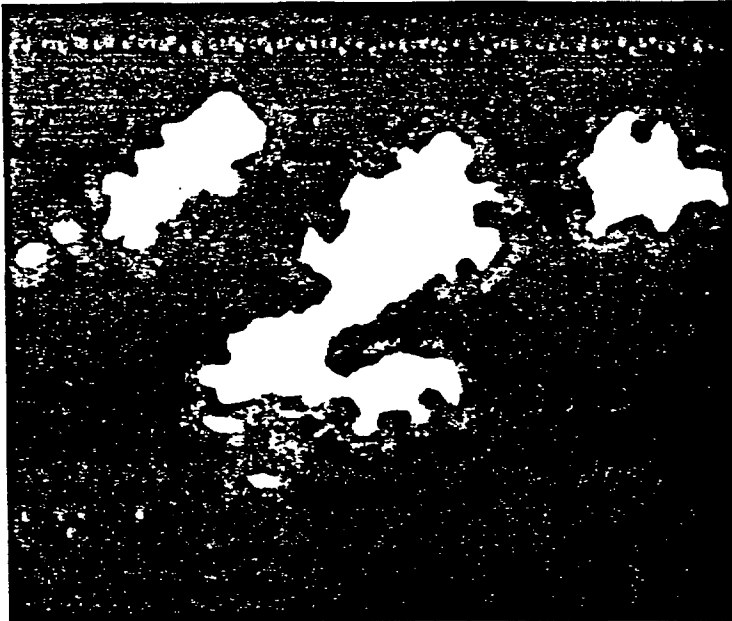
Roentgenogram of the same plaques as in Fig. 25.
